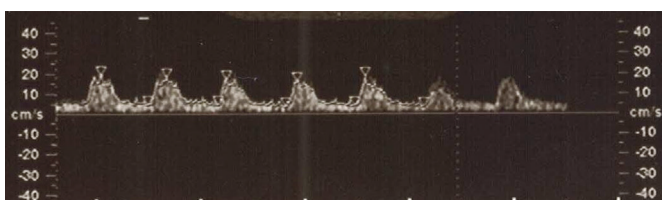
The usual spectre in ultrasound Doppler evaluation.
